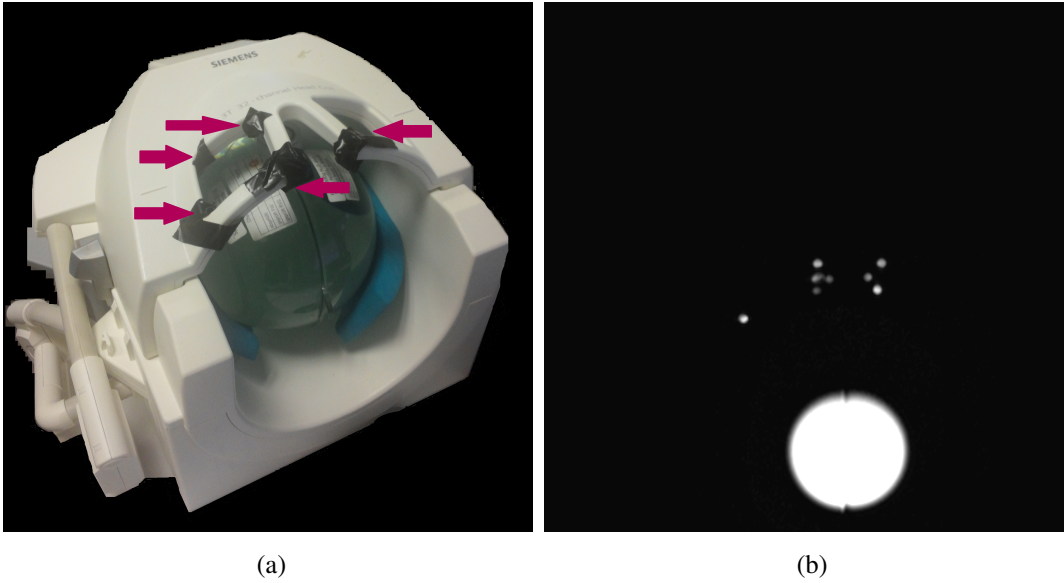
Experiment for the head coil location finding with respect to the MRI machine iso-center using oil pill markers. (a) Head coil with fish oil pills used as markers. Pill positions are shown with red arrows. (b) An image slice taken for finding the exact positions of the markers and therefore the head coil position were calculated precisely.
